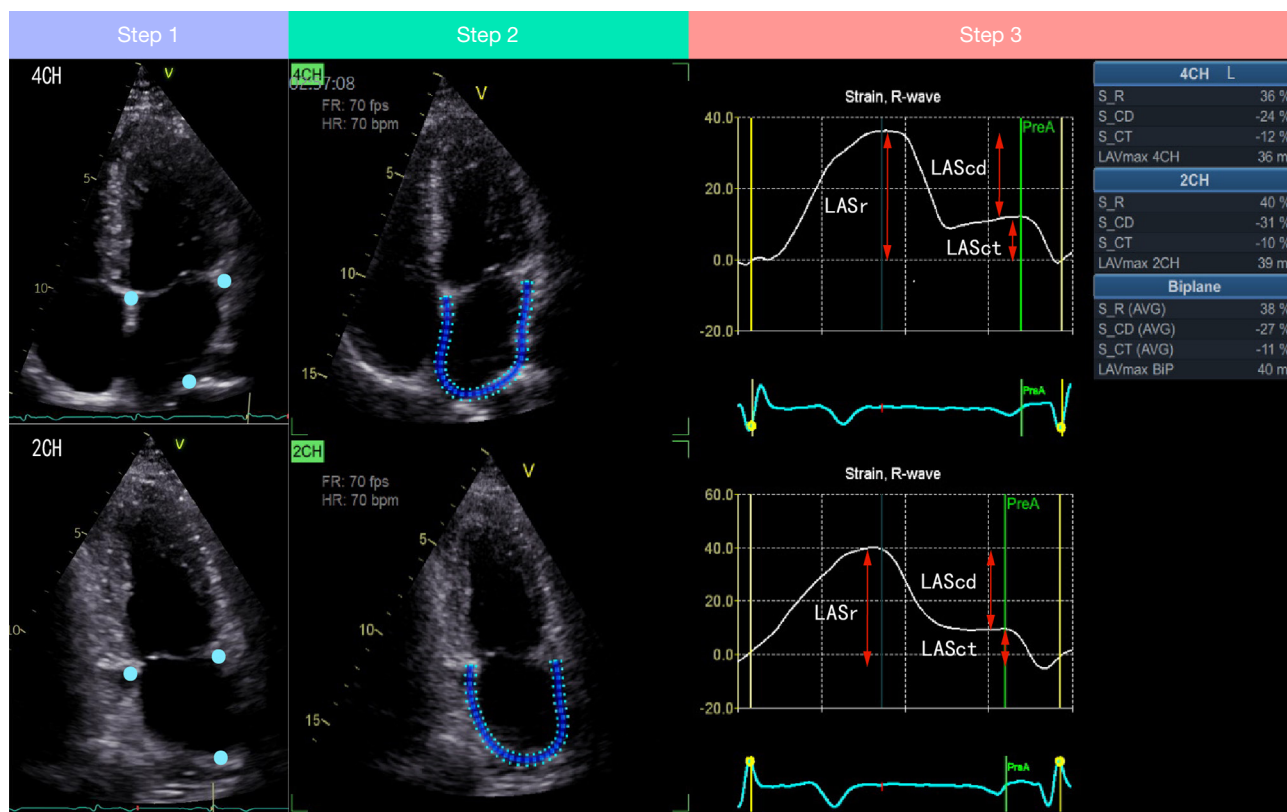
Specific steps for measuring left atrial strain using speckle-tracking echocardiography. Step 1, the apical four-chamber view sequentially depicts the three reference points at the base of the left atrium on the septal side, the lateral wall side, and the top of the left atrium (the blue dots in Step 1); the apical two-chamber view sequentially depicts the three reference points at the base of the left atrium on the anterior wall side, the posterior wall side, and the top of the left atrium (the blue dots in Step 1). Step 2, the application tracks the mobility of the left atrial myocardium automatically and allows the region of interest to be manually adjusted (the blue area in Step 2). Step 3, the software determines the left atrial strain curves, left atrial reservoir, conduit, and contractile strain values, as well as the average strain values for each of the apical four-chamber and apical two-chamber views based on the left atrial myocardial “speckle” motion. 4CH, apical four-chamber view; 2CH, apical two-chamber view; LASr, left atrial reservoir strain; LAScd, left atrial conduit strain; LASct, left atrial contractile strain.
